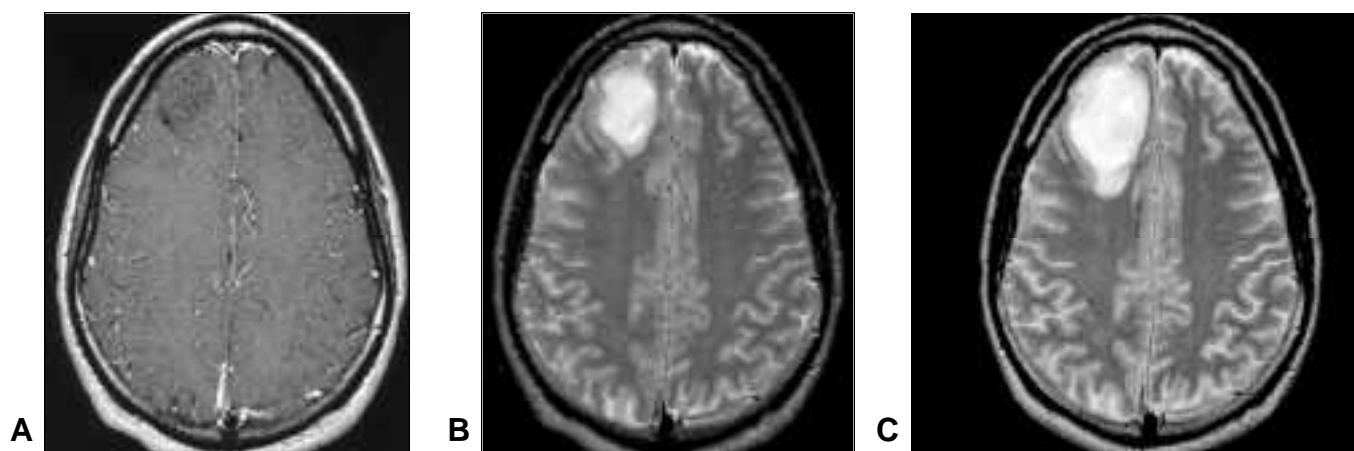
Low-grade oligodendroglioma. Twenty-eight-year-old man presenting with generalized seizures. MRI showed well-demarcated right frontal lobe mass with low-signal intensity and no enhancement with gadolinium-DTPA contrast on T1-weighted scan (A), and high signal intensity and little surrounding edema on T2-weighted scan (B). These radiographic features are characteristic for a low-grade glioma. Following radiographic progression (C), he underwent gross total resection of tumour. Radiotherapy and chemotherapy have been deferred without tumour progression over a follow-up period of over three years.
